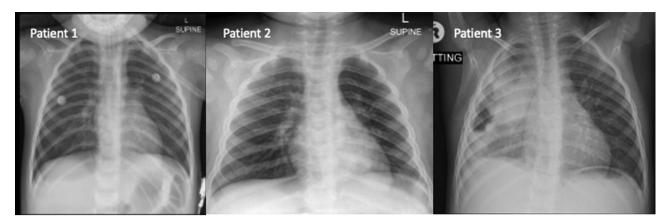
Patient 1: Frontal chest radiograph in a high care setting with a well-placed endotracheal tube tip and nasogastric tube tip. Lung volumes are on the large side but this is in the context of positive pressure ventilation which accounts for this. There is no confluent parenchymal air-space disease or any suggestion of an interstitial process. Patient 2: Frontal chest radiograph demonstrating confluent density behind the heart on the left in keeping with left lower lobe air-space disease. Patient 3: Frontal chest radiograph demonstrating extensive confluent air-space disease with some volume loss involving the right upper lobe and right lower lobe. There are features of a right pleural effusion. The bronchus intermedius and possibly right upper lobe bronchus are narrowed suggesting compression by right hilar and subcarinal lymphadenopathy. The trachea is also bowed and displaced to the left in keeping with right paratracheal lymphadenopathy. Features are of airway compression suggest pulmonary TB with associated complications of parenchymal collapse/consolidation and pleural effusion.
